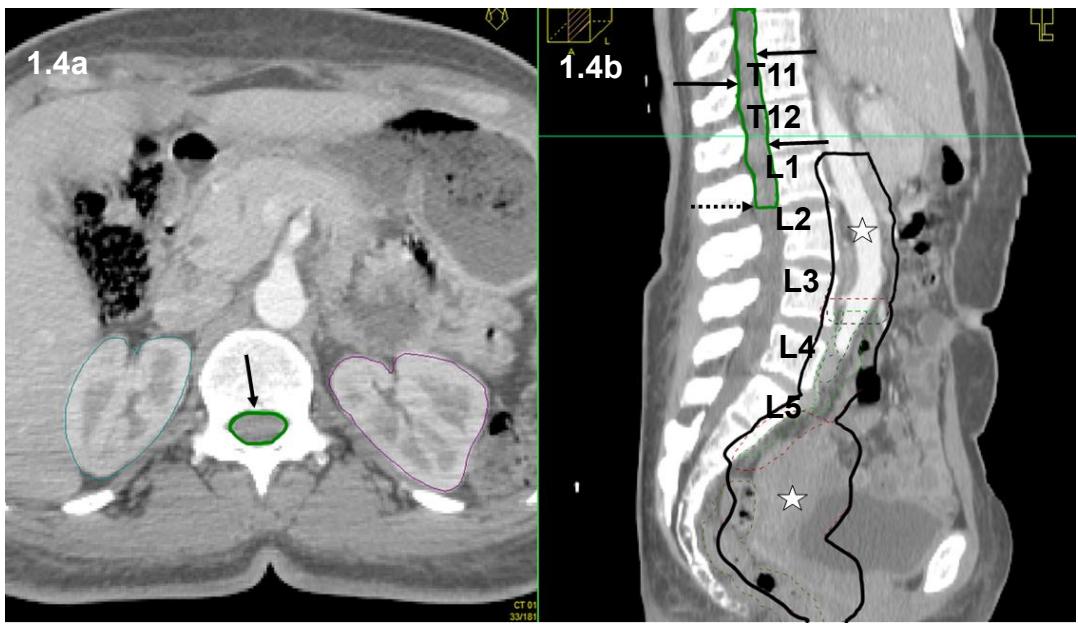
Axial (a) and sagittal (b) CT of para-aortic radiotherapy where PTV (star) extends to the superior border of L2. Spinal canal (solid arrows) has inferior level at the lower border of L1 (dashed arrow)
